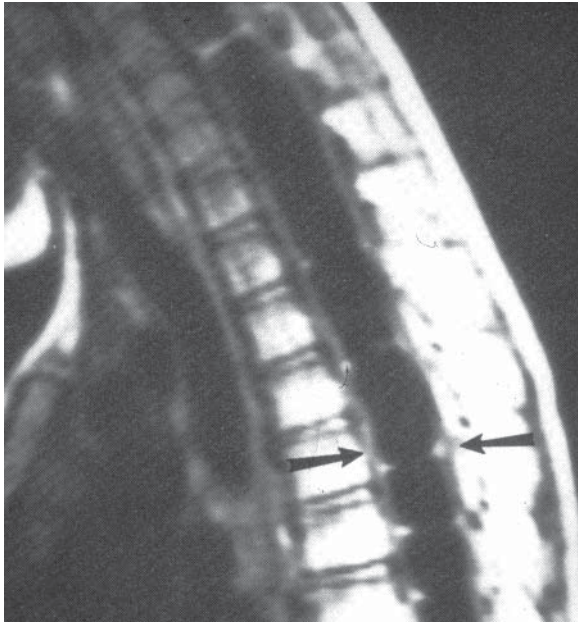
T1-weighted sagittal MRI noting the large syrinx found in our patient (between arrows).
